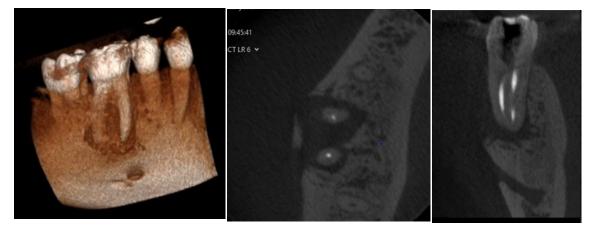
Dehiscence type bone loss on CBCT Scan.
